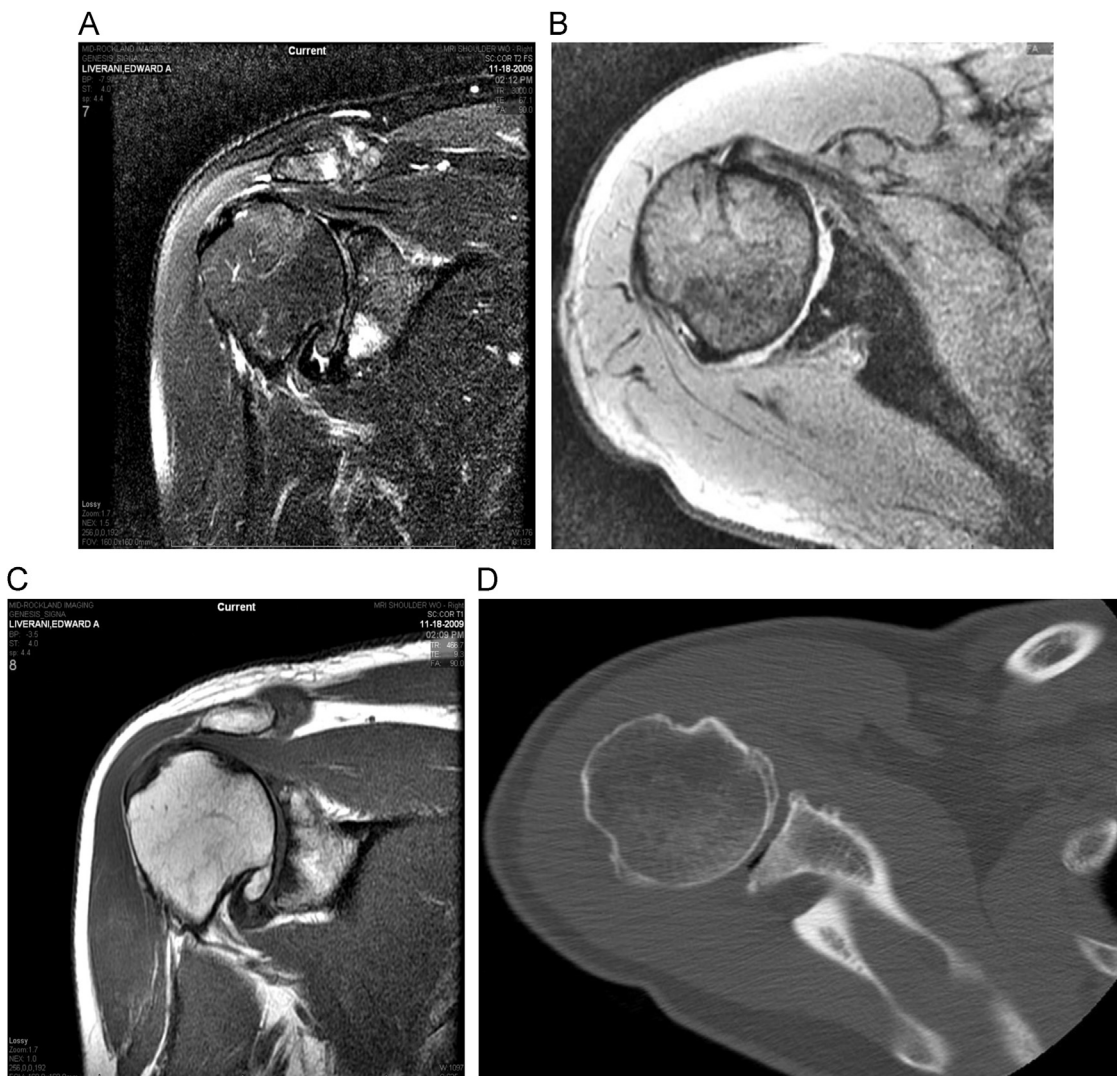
MRI and CT of a healthy 71-year-old patient with significant osteoarthritis of the glenohumeral joint. The patient is also noted to have his rotator cuff intact without superior head migration demonstrating no rotator cuff tear arthropathy.
